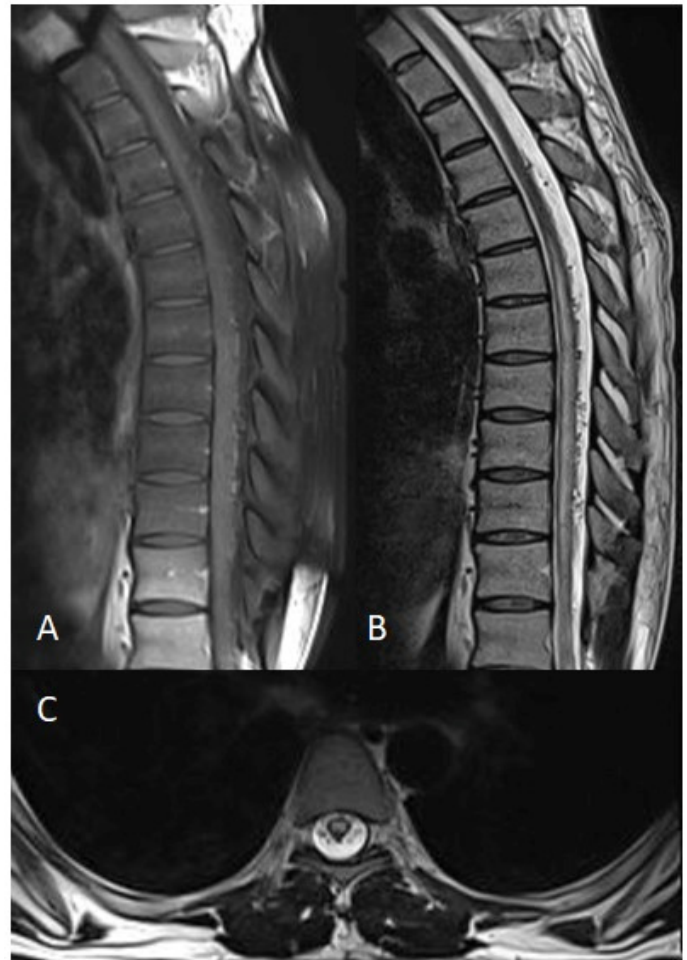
In spinal MRI examination, (A) heterogeneous enhancement in sagittal contrast-enhanced series, sagittal (B) and axial (C) hyperintense pathologic signal enhancement on T2 sequences of the spinal cord at the T5-L1 level and expansion in the spinal cord.
